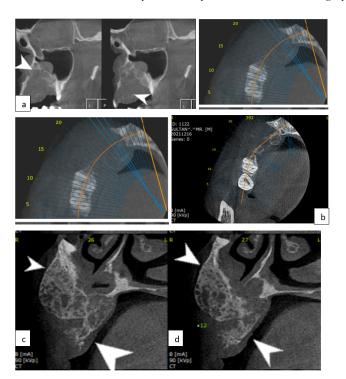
Recurrence of the lesion after 7 months with subsequent CBCT findings at the interval of 2 months post corticosteroid injection therapy. Although no significant decrease in size was noted yet some significant resistance was developed during intralesional injections
